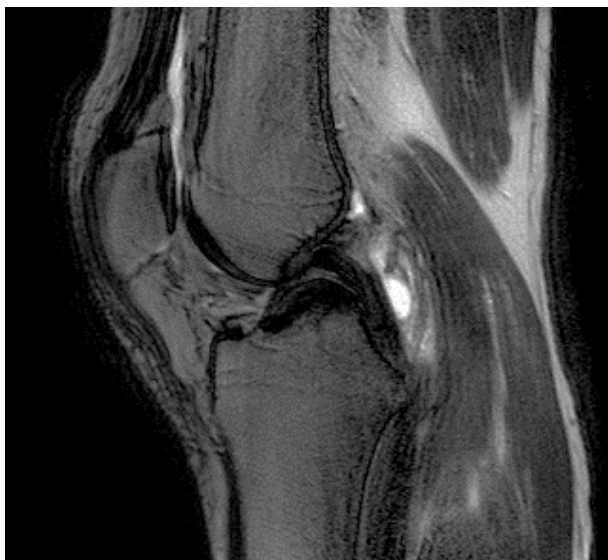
Same case of Figure 1, pre-operative MRI shows the “double PCL sign” (arrow shows PCL, arrowhead shows the meniscus tear)
